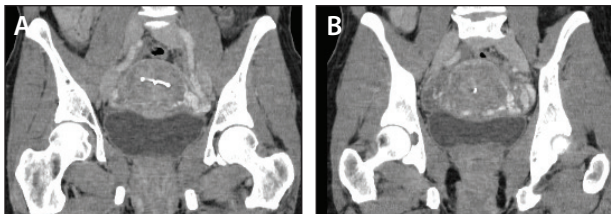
Case 2 preoperative CT scan showing 9-mm-diameter left ovarian vein (A) and large left-side pelvic varicosity (B).
